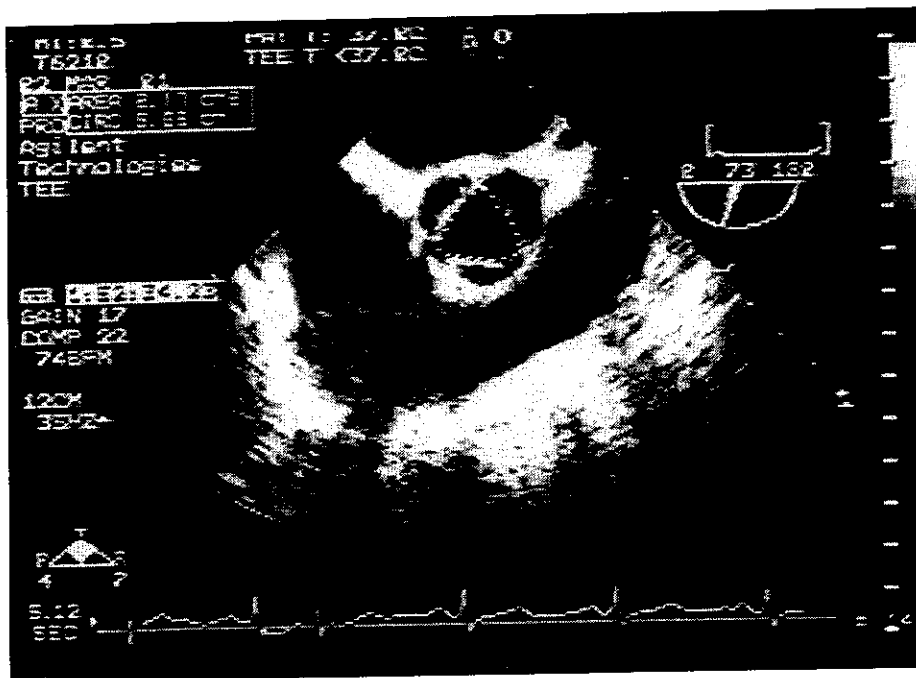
Two-dimensional multiplane esophageal echocardiographic image of the basal short-axis view of the aortic valve. Valve orifice planimetered using the triangular model.
